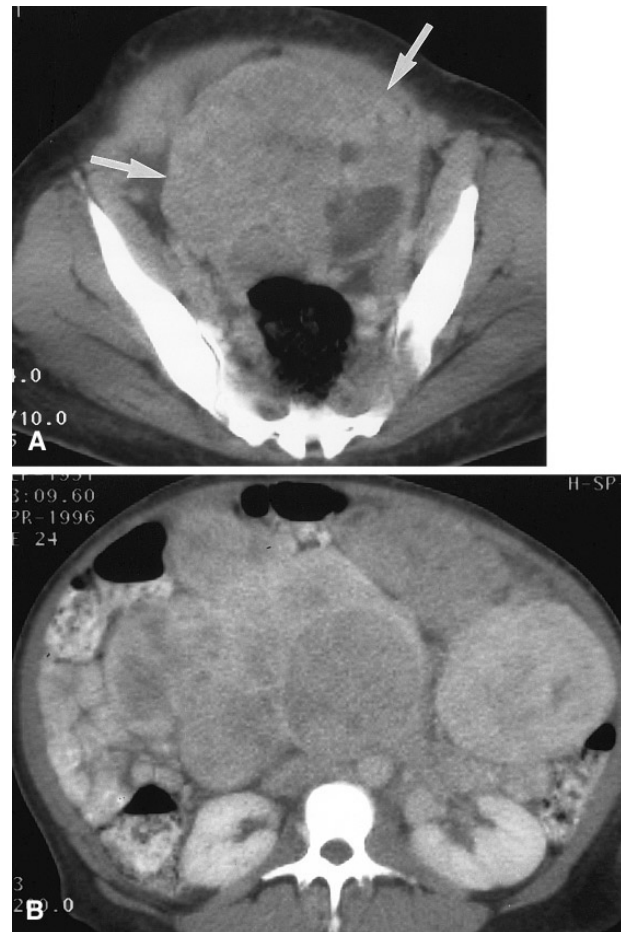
A Enhanced axial CT of the pelvis shows a heterogeneous mass (arrows) arising from a uterus involved by diffuse leiomyomatosis. B Enhanced axial CT obtained at the level of the kidneys demonstrates multiple, apparently separate masses resembling LPD. At laparotomy, these masses were found to be pedunculated uterine leiomyomas.
